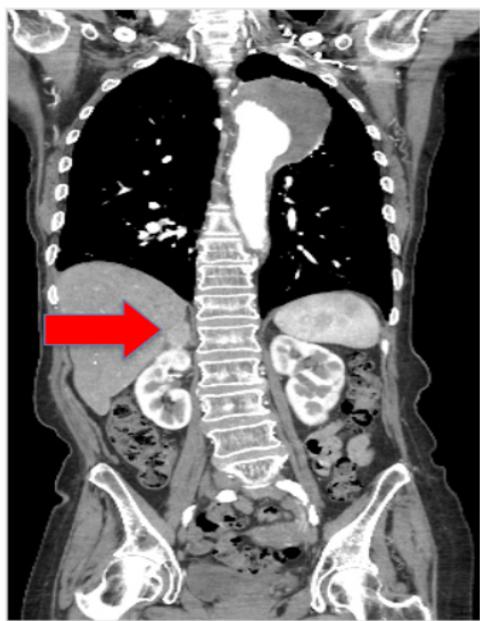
CT-chest/abdomen with contrast demonstrating 2.8 cm right adrenal mass.
